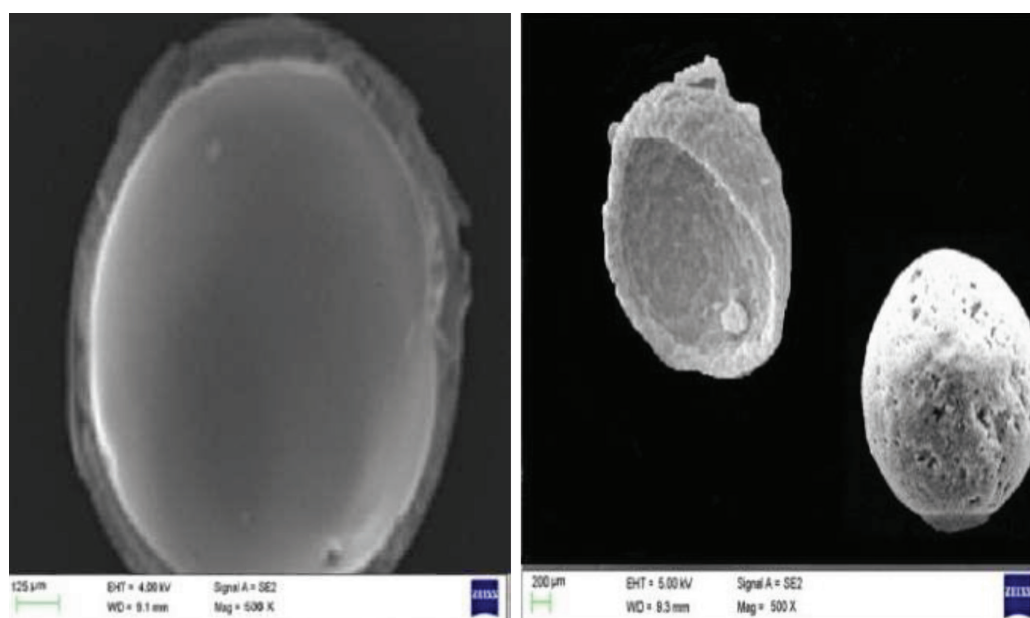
SEM images of optimised CT hydroxypropyl methylcellulose E50 microcapsules (F8)
